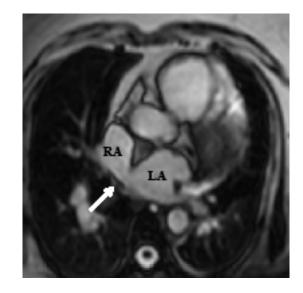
Cine MRI of a sinus venosus atrial septal defect (arrow). RA, Right atrium; LA, Left atrium
